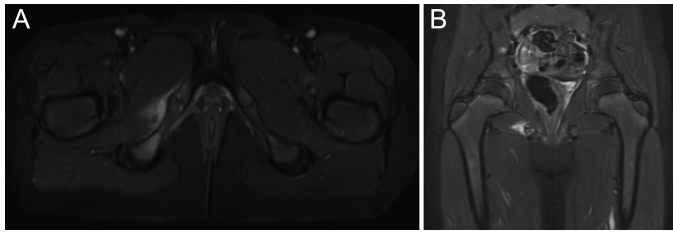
(A, B) Axial and coronal T2-weighted magnetic resonance images. Signal intensities are compatible with soft tissue edema at the surrounding muscles of the right ischiopubic synchondrosis. Enlargement and minimal irregularity of right ischiopubic synchondrosis are detected when comparing left side.
